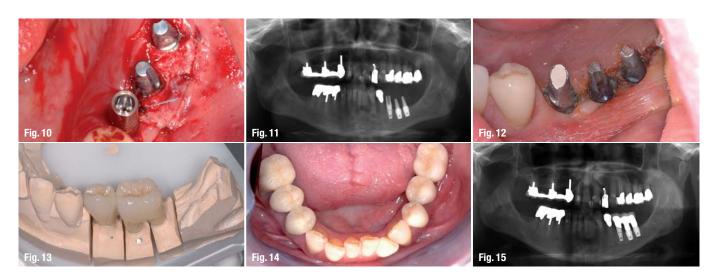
11_ Post-operative X-ray after exposure.
